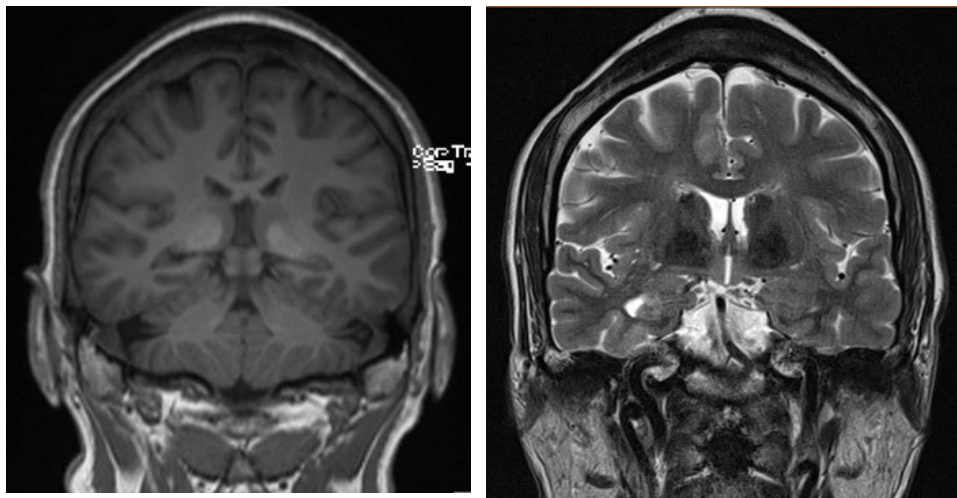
Coronal T1 and T2 brain MRI sequences.
